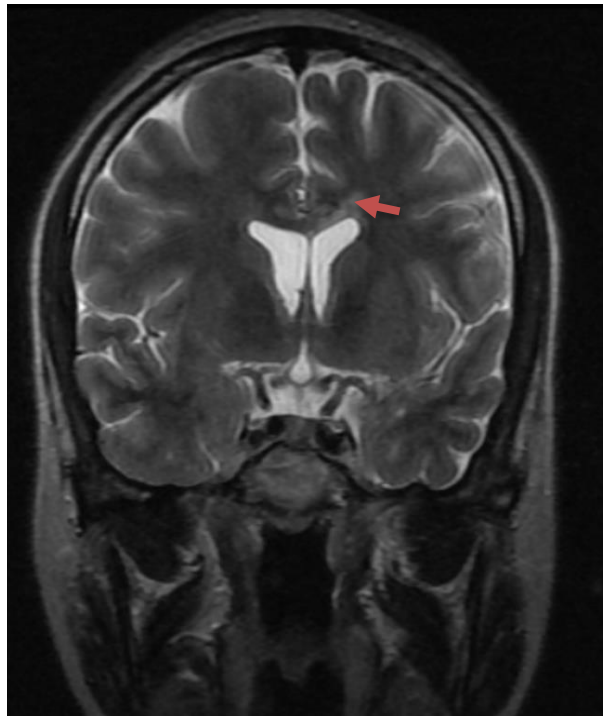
Coronal T2-weighted MRI confirming hyperintense white matter lesions in the left cerebral hemisphere (orange arrow).
